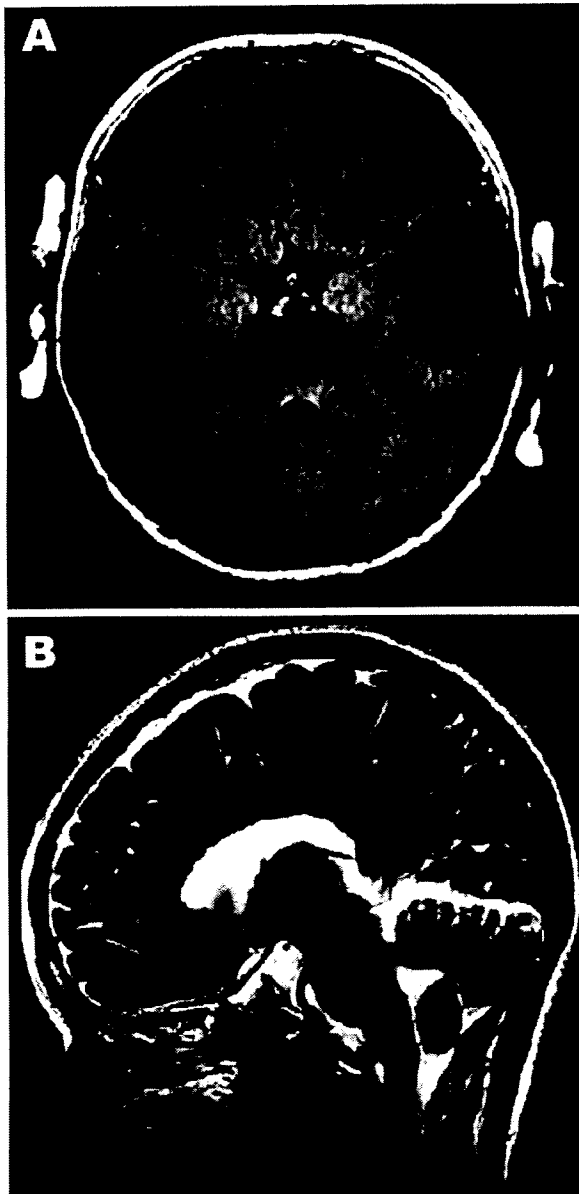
Magnetic resonance images of the brain. A) Hyperintense lesions in the tegmentum of the pons in the axial section of the fluid-attenuated inversion recovery image. B) In the sagittal section of the T2-weighted image, hyperintense lesions are present in the tegmentum of the midbrain, pons, and medulla oblongata.
